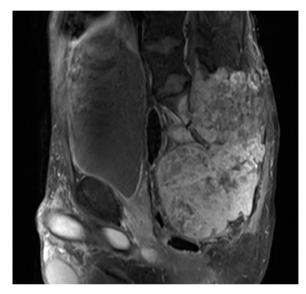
T2 weighted saggital MRI show large lobulated chordoma invading soft tissues. Anterior extension of the tumor is seen in less than 25% and is probably due to the tough sacral fascia present on the anterior part of the sacrum10,14,24.
